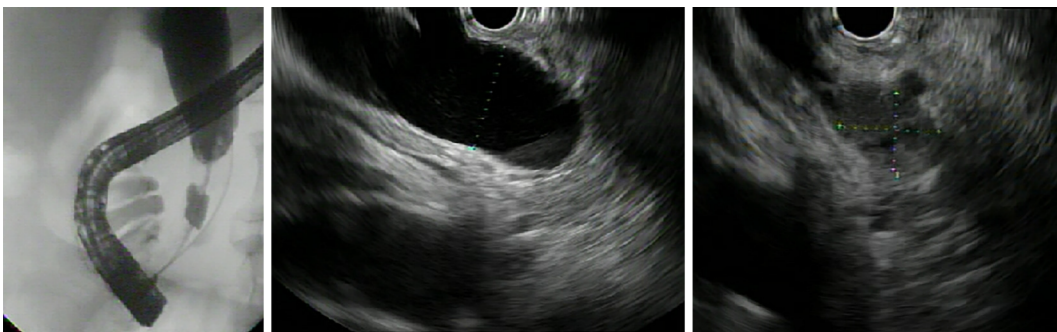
Diagnosis of cholangiocarcinoma of the distal tract of the main biliary duct, obtained in a single session by biopsy during endoscopic retrograde cholangiopancreatography and endoscopic ultrasound-guided fine needle aspiration. Endoscopic ultrasound images show dilation of the common bile duct and stenosis of the distal tract due to a neoplastic nodule.
